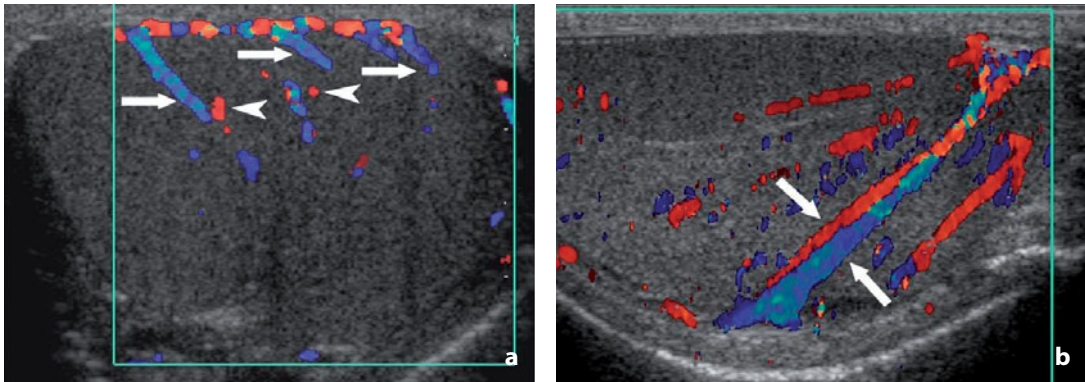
Normal anatomy. Normal intratesticular vessels. a Sonogram shows the vessels which from the periphery run within the testis (*blue vessels – arrows*). The *arrowheads* indicate the recurrent rami radiating towards the periphery. b A transtesticular artery and corresponding vein are well visualized (*arrows*)
